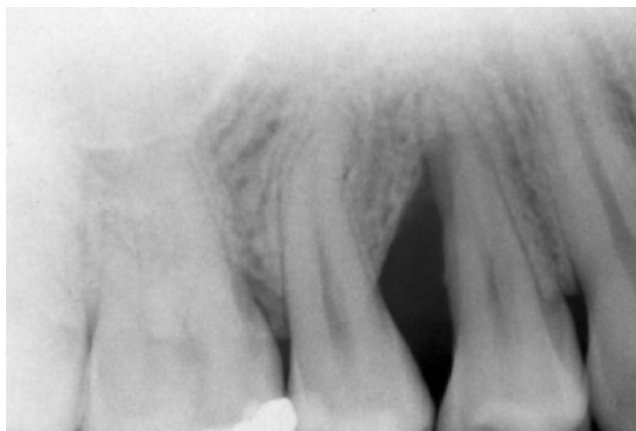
The preoperative X-ray revealed the presence of an intrabony defect.
